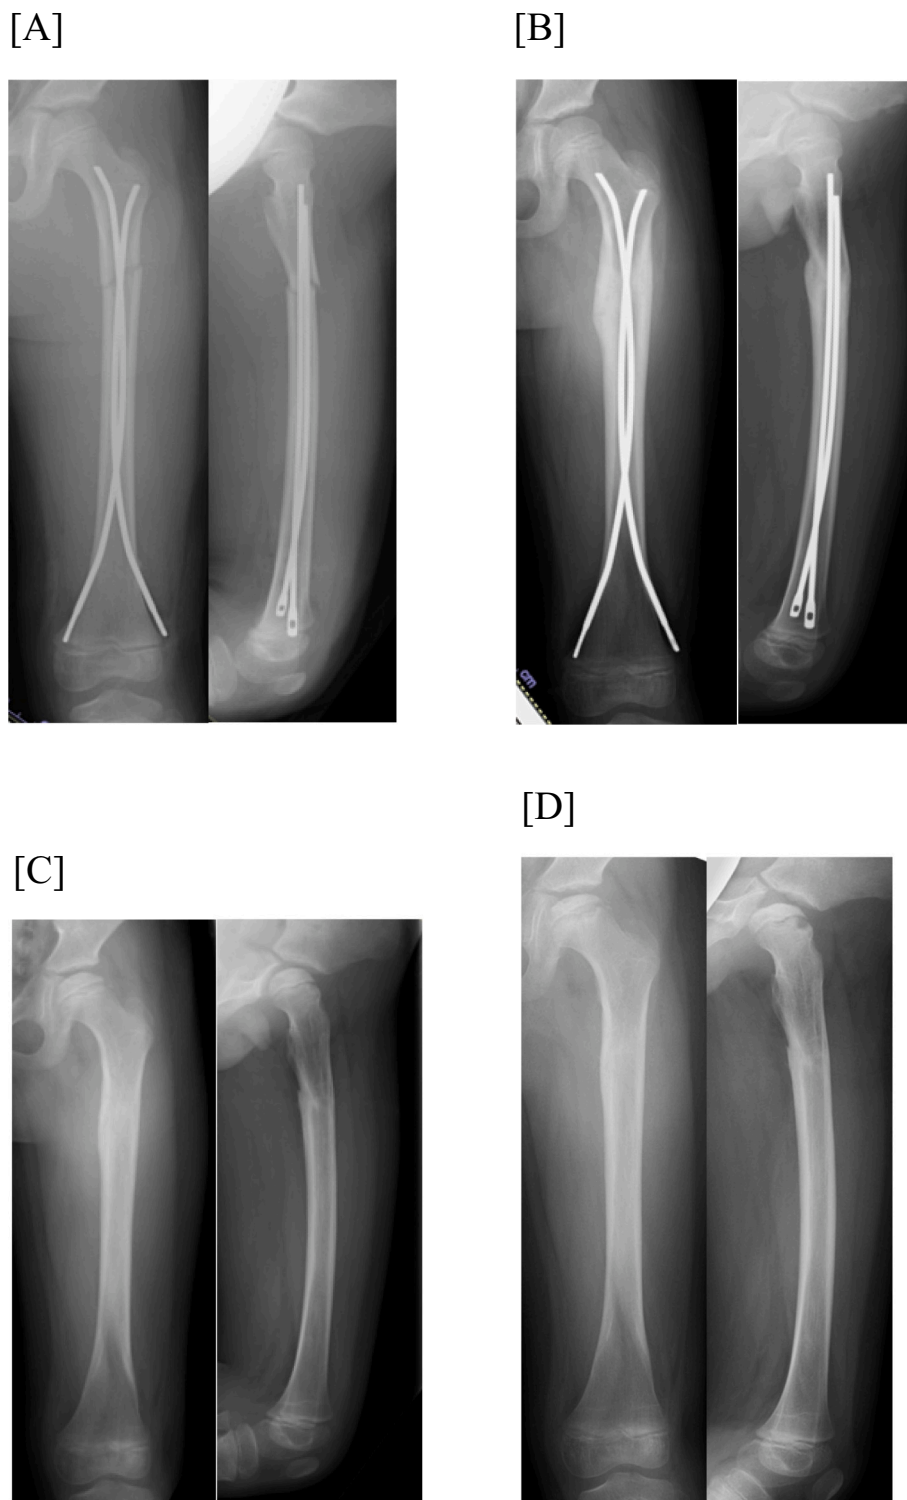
Anteroposterior (AP) and lateral radiographs taken [A] immediately postoperatively, [B] 8 months postoperatively, [C] 10 months postoperatively, and [D] 1 year postoperatively.
